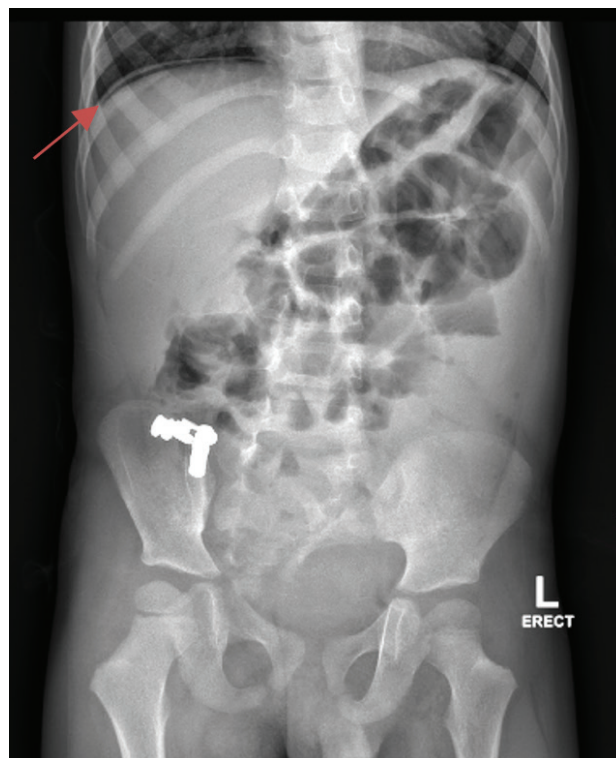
X-ray displaying the presence of free air under the diaphragm, as indicated by the arrow.
